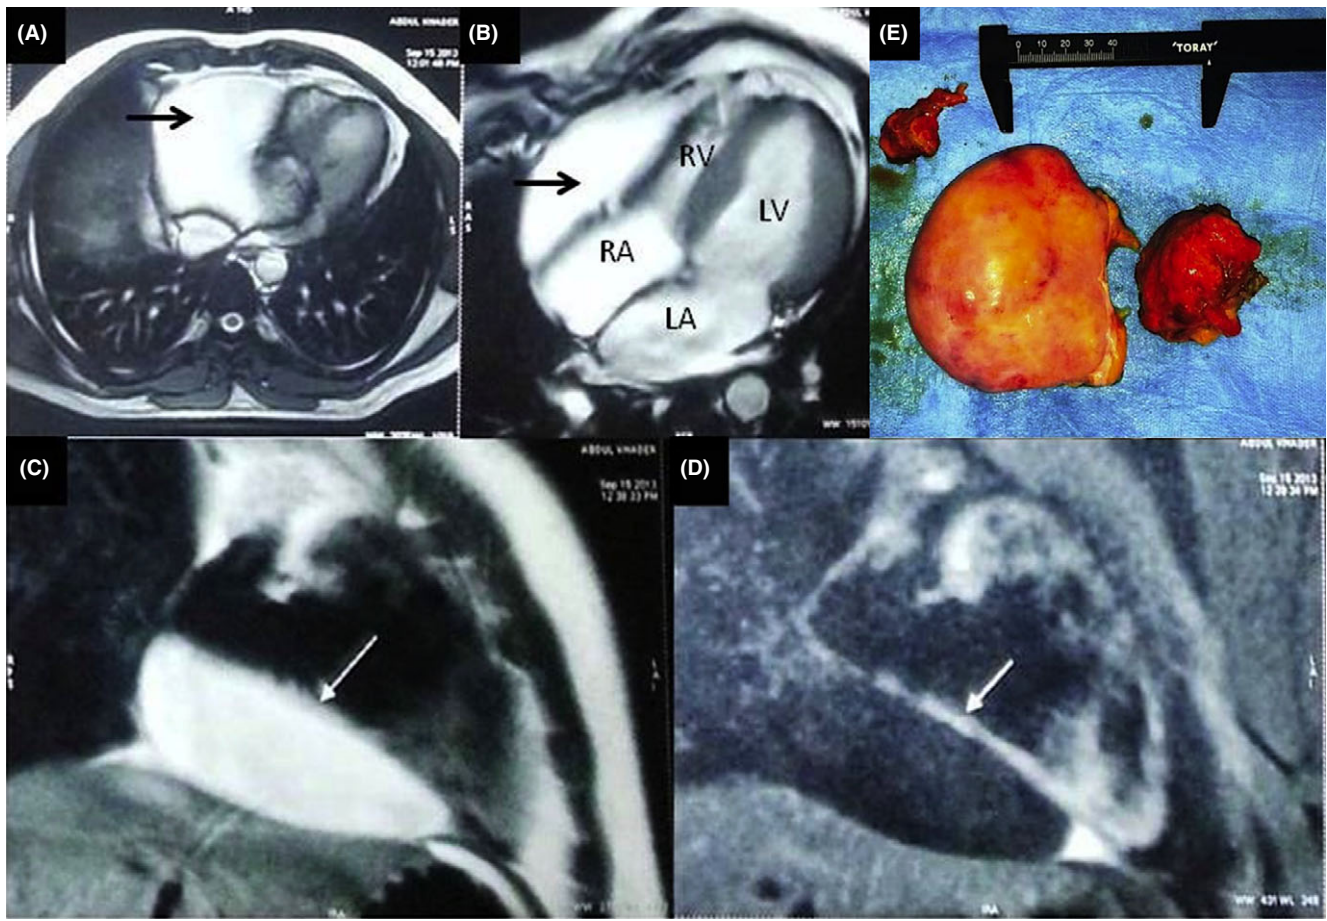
Cardiac magnetic resonance imaging: A, B, T1-weighted images reveal a circumscribed hyperintense mass located subepicardially to the lateral and inferior aspects of the RA and RV. C, D, A comparison of a T1 image (C) and a fat suppression sequence (D) of the subepicardial mass in the same view. The radiolucent appearance of the mass in the subepicardial location in fat-suppressed sequences suggests a lipoma. E, Gross appearance of the excised tumor shows a large circumscribed, encapsulated, bilobed tumor measuring $10 \times 10 \times 9$ cm with an intervening stalk. RA, right atrium; RV, right ventricle. (From Ref. 26 with permission)
